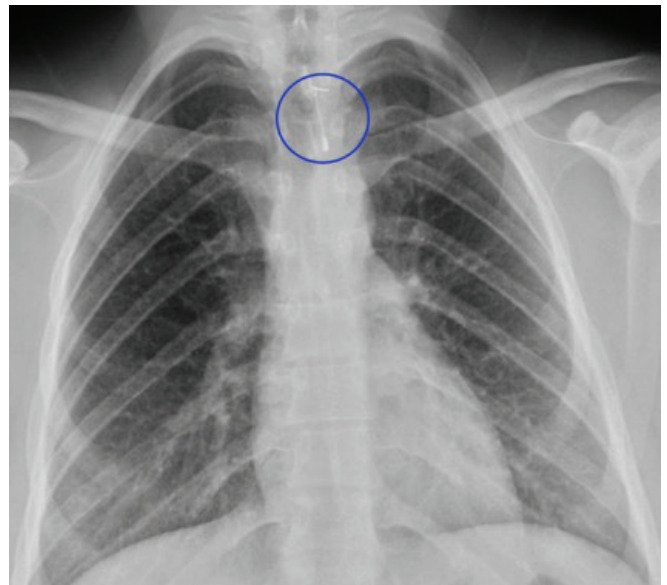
Posteroanterior chest radiography showing a foreign body in the upper mediastinum (blue circle).
